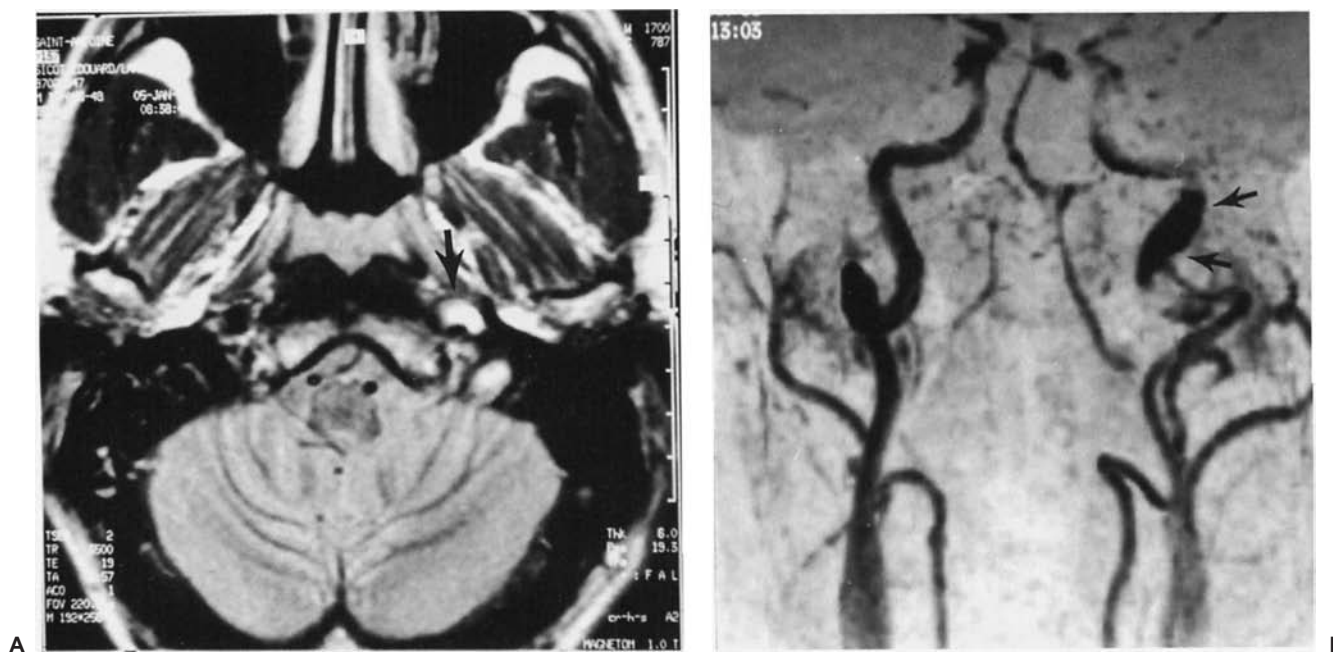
Dissection localized to the petrous segment of the left extracranial internal carotid artery. A: Axial T2-weighted imaging of the brain demonstrating a typical eccentric hyperintense signal of the internal carotid artery corresponding to the mural hematoma (arrow) surrounding the residual lumen. B: Magnetic resonance angiography showing a left internal carotid artery stenosis associated with a subpetrous hematoma (arrows) with increased external diameter typical of dissection.
